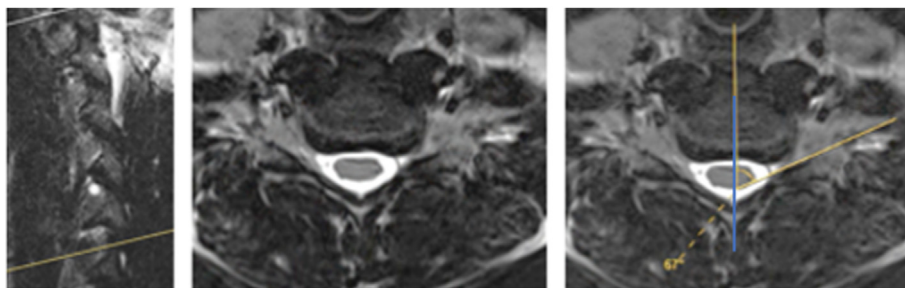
Sagittal and axial T2 MRI. In preparation for a left C6/7 TFESI, the axial slice was selected at the inferior portion of the foramen. The ventral surface of the SAP angle is measured in relation to the sagittal line through the spinous process and mid portion of the disc or vertebral body. In this case, the SAP angle measured 67°.
